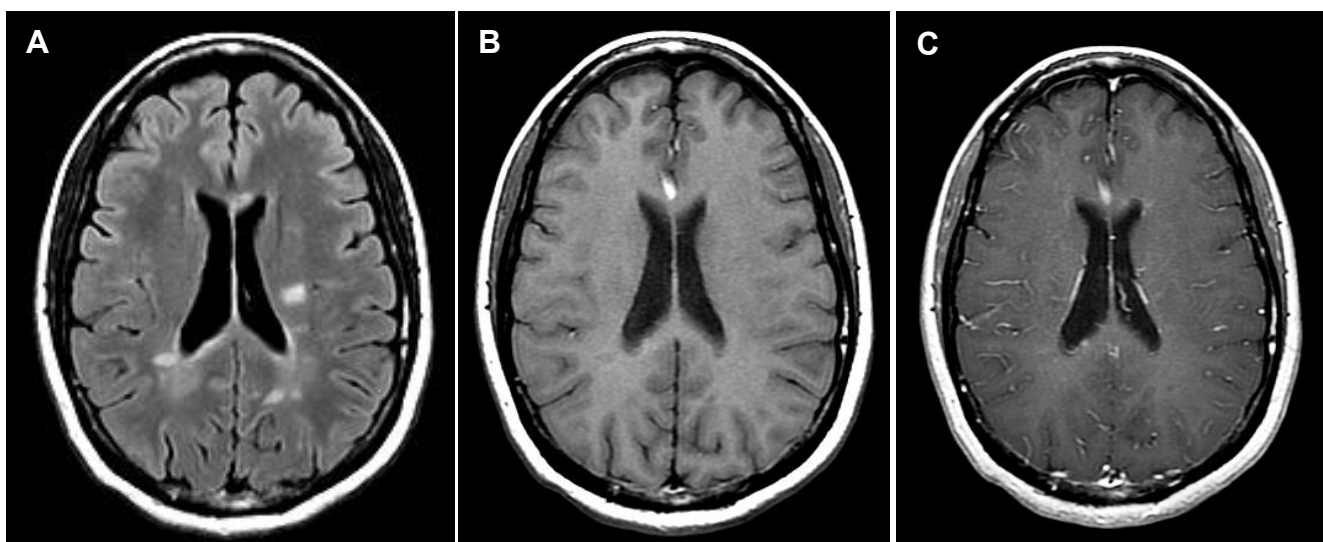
Demonstration of non-enhancing MS lesion. (A) Axial T2 FLAIR displaying several MS plaques in the periventricular white matter. (B) Precontrast spin echo T1W image of the same location. (C) Same location postcontrast spin echo T1; note the lack of contrast enhancement.
